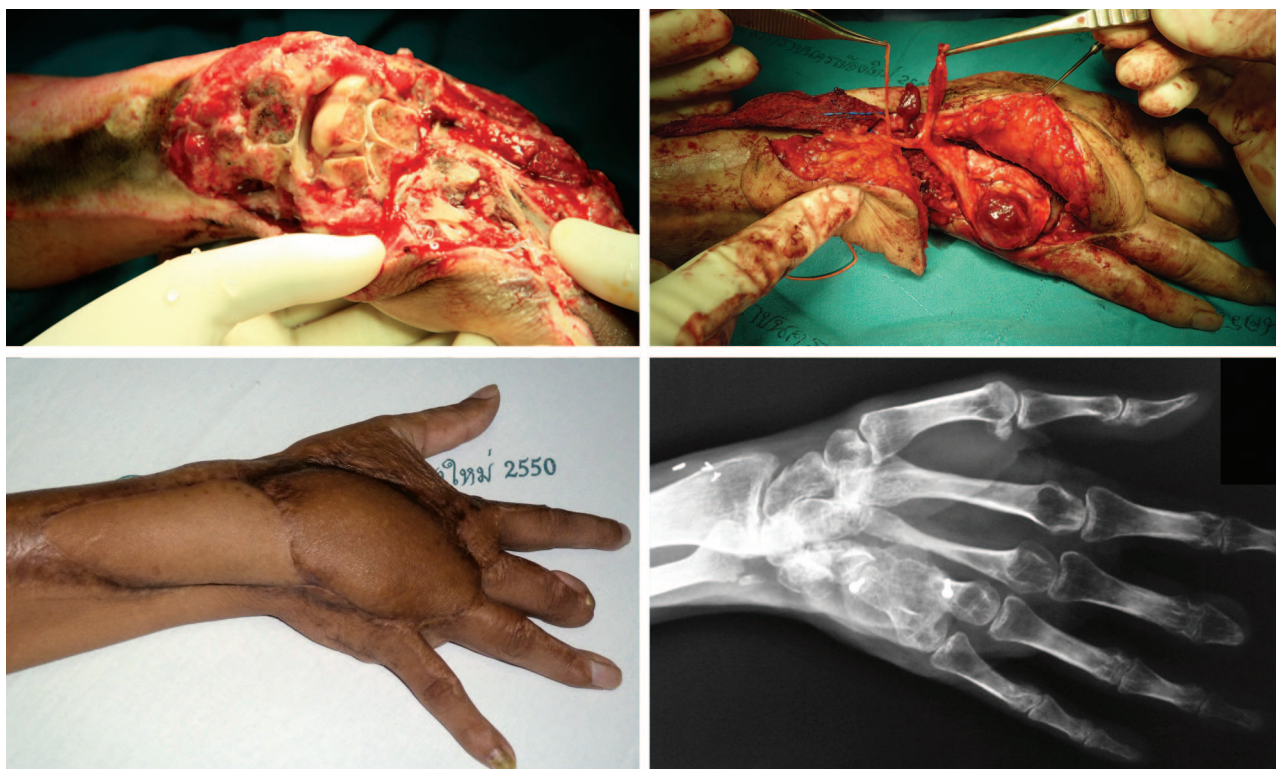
Case 2. Bone and skin injury of the right hand before reconstruction (*above, right*). The inseting of the chimeric osteocutaneous flap, using the descending genicular artery osteoarticular and descending genicular artery perforator with the vastus medialis from the middle third of the descending genicular artery (*above, left*). The same hand after successful osteocutaneous descending genicular artery flap surgery, 4 months after reconstruction (*below, left*). Radiograph of the same hand showing bony union 4 months after reconstruction (*below, right*).
